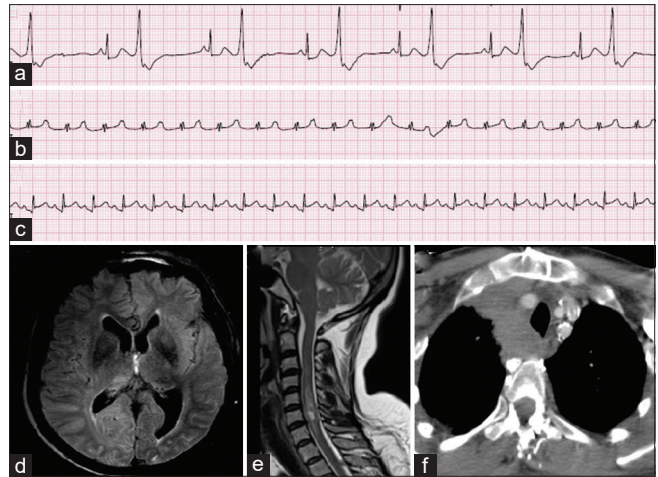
Concomitant illnesses in Crisis. (a) 49-year-old with ventricular bigeminy, (b) 62-year-old with junctional tachycardia aggravated by pyridostigmine, (c) 57-year-old with diffuse ST elevation and ECHO showing pericarditis, (d) 64-year-old with invasive thymoma and encephalopathy, MRI showing FLAIR sulcal changes in insular cortex and parieto-occipital lobes, (e) 23-year-old with MRI showing cervical cord hyperintensity, (f) 33-year-old with dyspnea and features of thymoma recurrence with superior vena cava syndrome and airway infiltration
